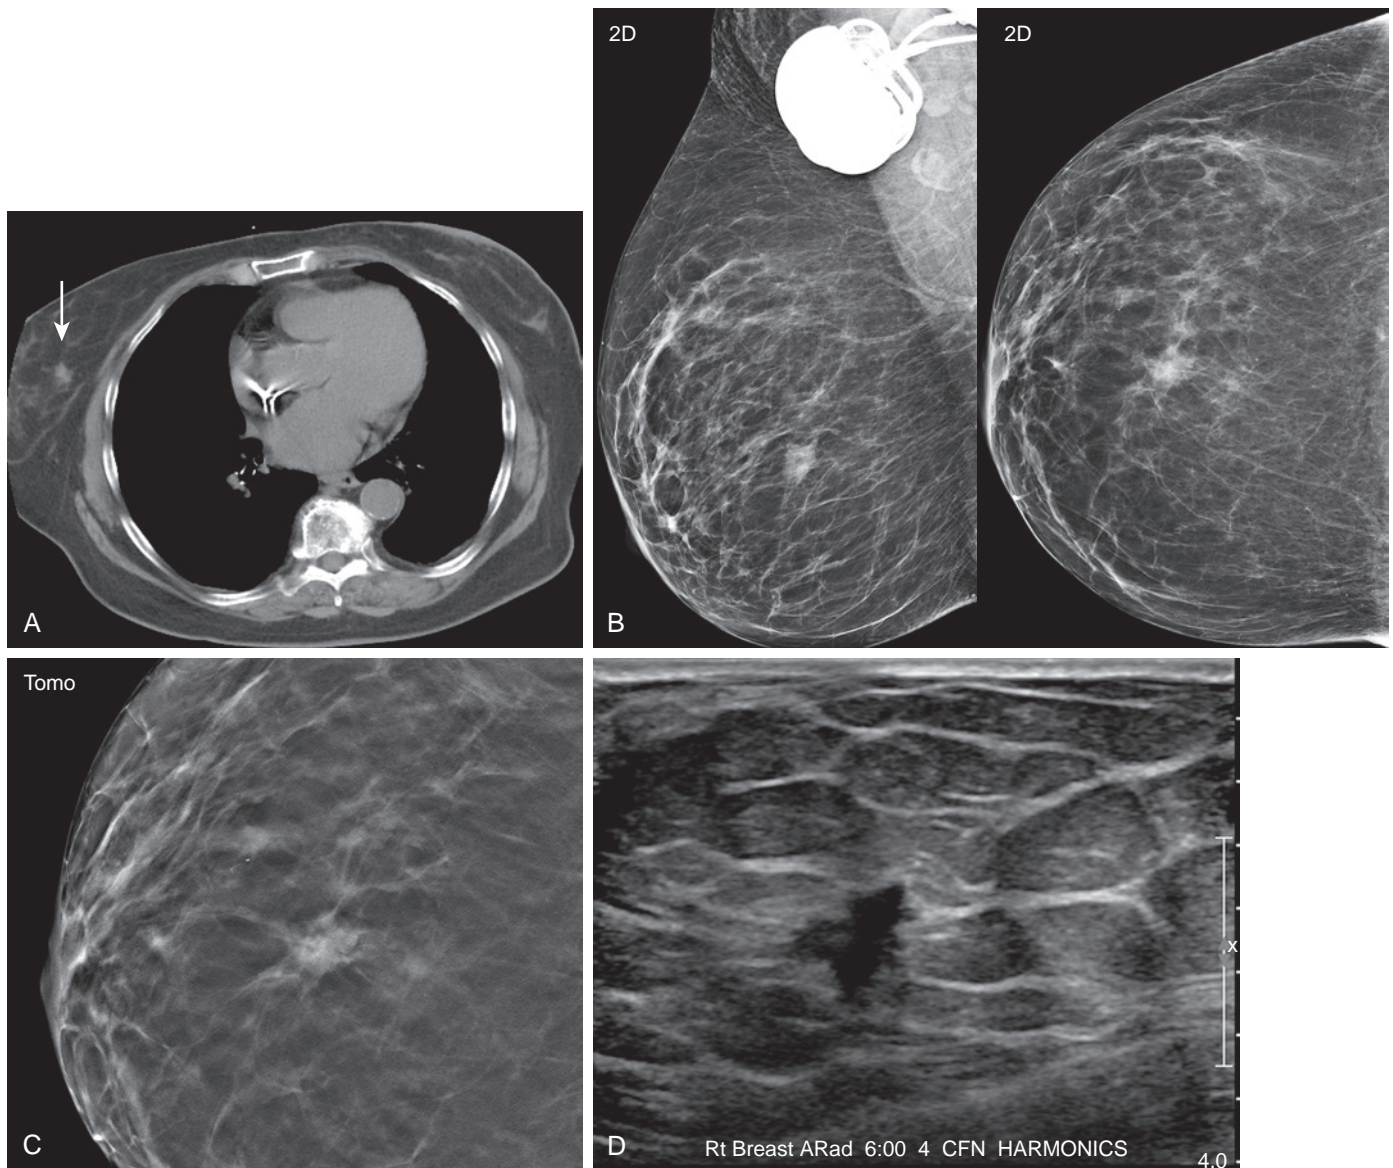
(A) An 82-year-old woman underwent a chest computed tomography scan (for unrelated medical reasons), which demonstrates a spiculated mass in the right breast. (B) Diagnostic mammography was then performed, which shows a 1.2-cm irregular mass in the right breast central to the nipple. (C) Tomosynthesis better depicts the spiculated margins. (D) Targeted ultrasound demonstrates a lobulated hypoechoic mass with an irregular margin. Ultrasound-guided biopsy revealed a moderately differentiated infiltrating ductal carcinoma, ER+/PR+/Her2–.
